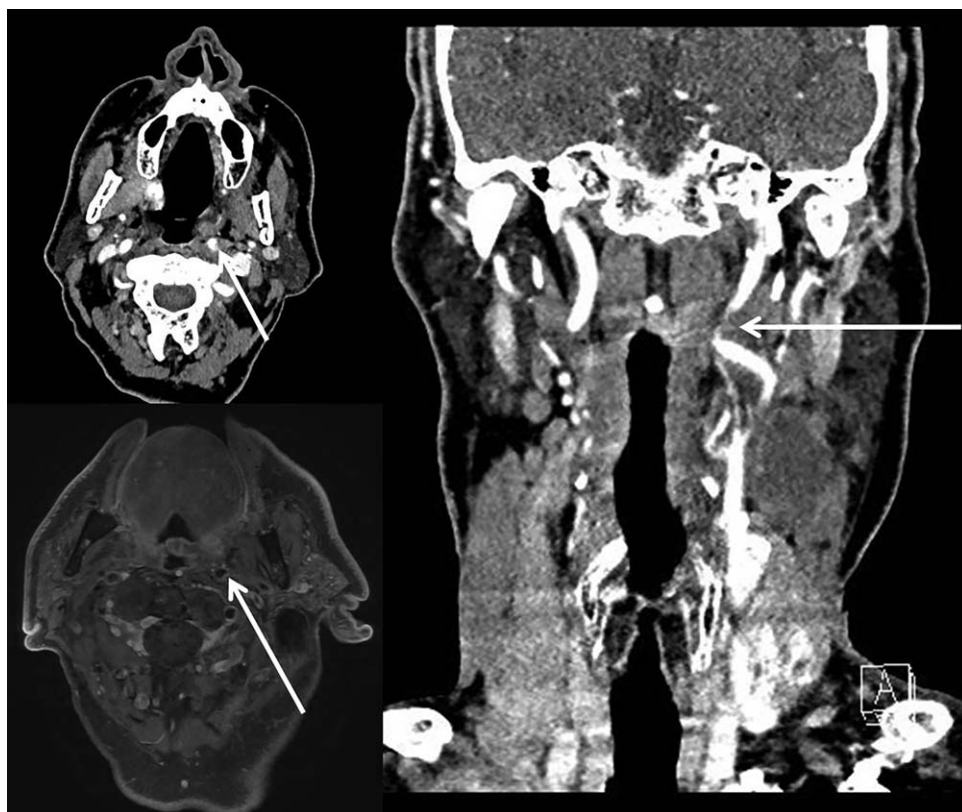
Preoperative MRI and CT scan of patient number 1, who presented with a T2N2b squamous cell carcinoma of the left glosso-tonsillar sulcus. The internal carotid artery (ICA) formed a retropharyngeal loop that was in close proximity to the posterior limits of the tumor (white arrow). The patient underwent a complete transoral robotic surgery (TORS) resection via a cervical-transoral robotic approach with a free flap reconstruction.
